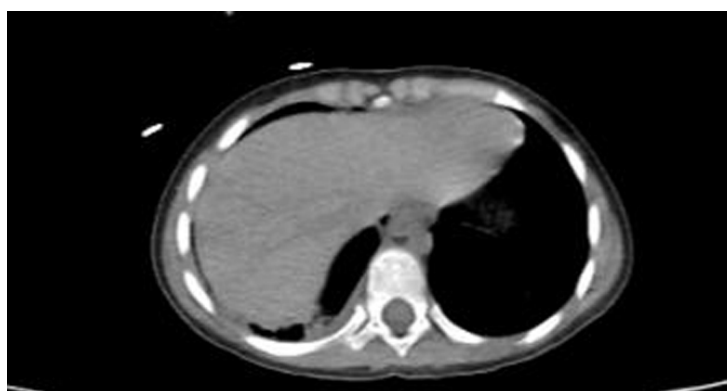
thoracic CT scan in the axial plane showing ground glass appearance in the base of both lungs
